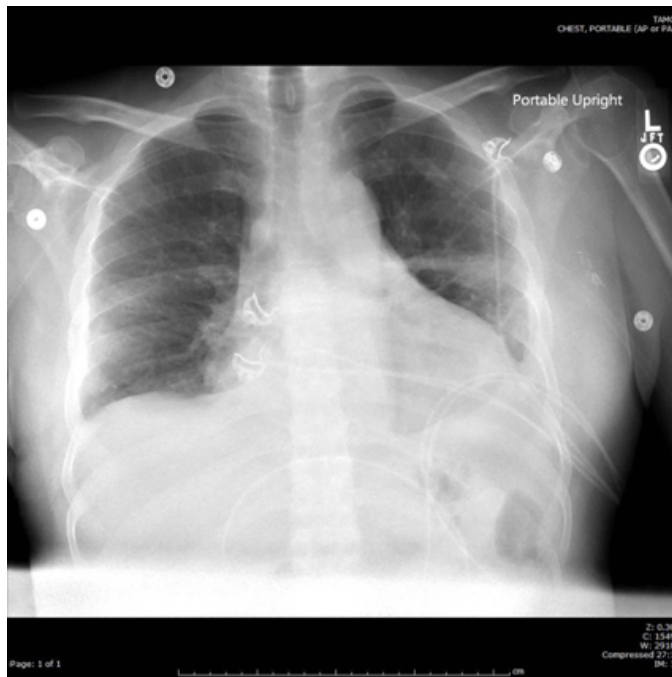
Chest radiograph on admission revealing bilateral pleural effusions and cardiomegaly.
